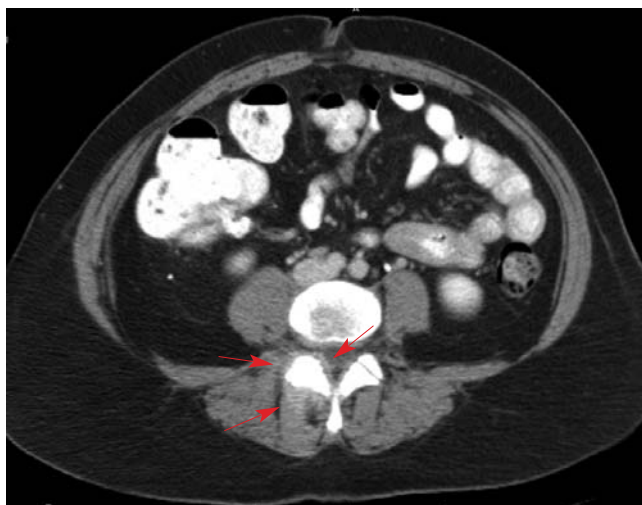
Contrast-enhanced CT demonstrates joint, paraspinal, and ligamentum flavum enhancement at the right L4-5 facet joint (arrows).
